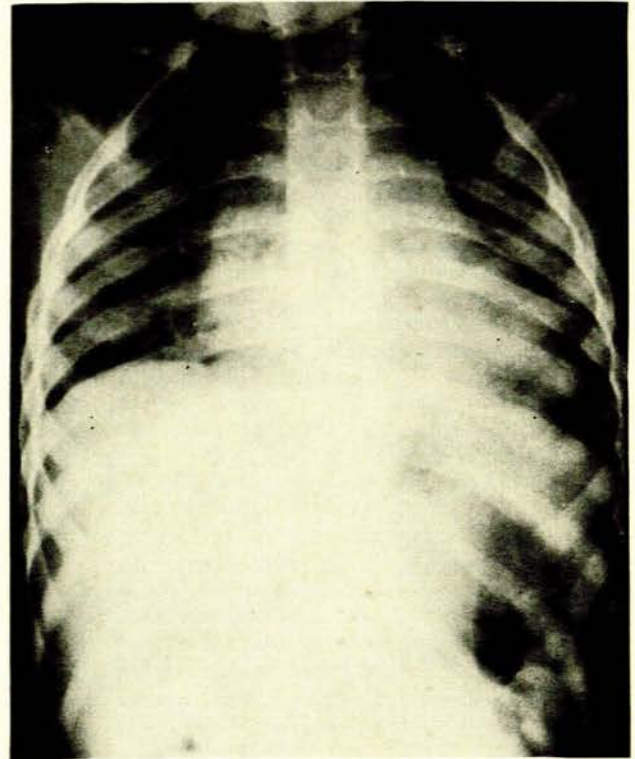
Chest X-ray. Note the wide superior mediastinum due to the ascending left superior vena cava, large superior vena cava, dilated main pulmonary artery and increased pulmonary vascular markings.
